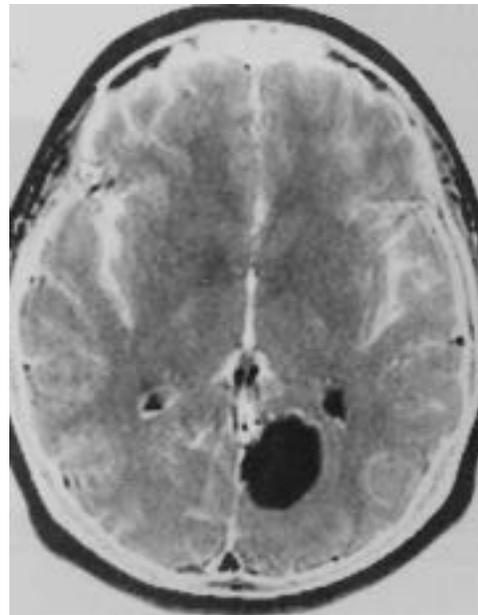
Axial postcontrast T1-weighted magnetic resonance imaging. Small posterior third falx meningioma just above the junction with the tentorium.
